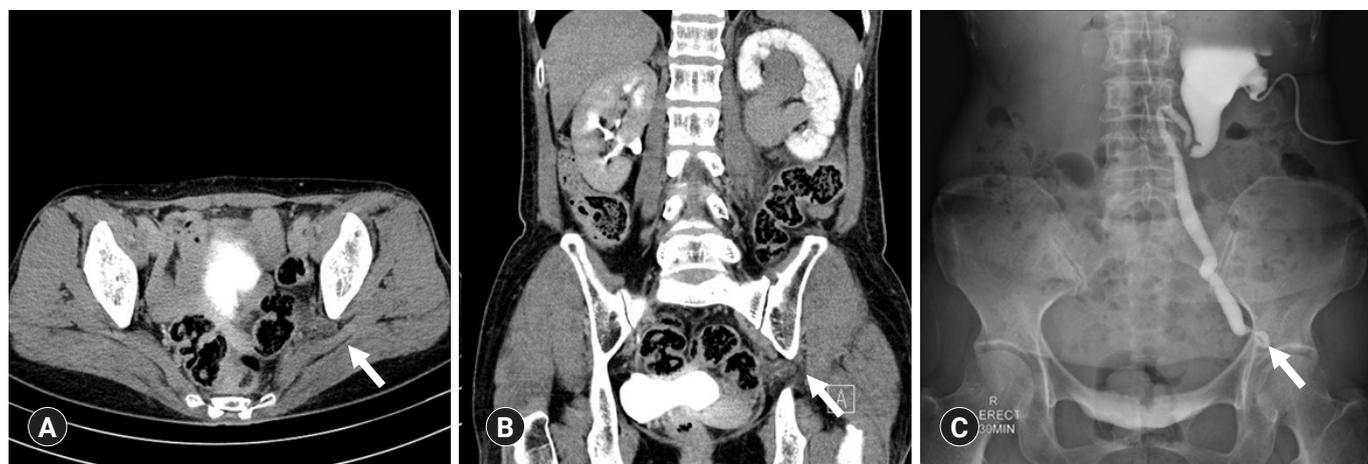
Postcontrast axial (A), coronal (B) computed tomography (CT), and a left anterograde pyelography (AGP, C) show left hydronephroureter with herniation into sciatic foramen (arrows). These CT and AGP reveal a 'curlicue ureter' sign as the knuckle of the herniated ureter passed laterally to the medial wall of the pelvis (arrows).
